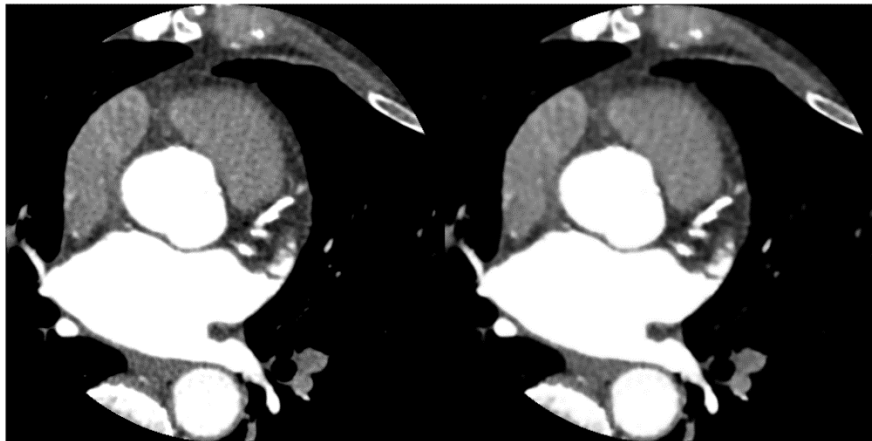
CT slice before and after applying the linear inhomogeneous isotropic filter
